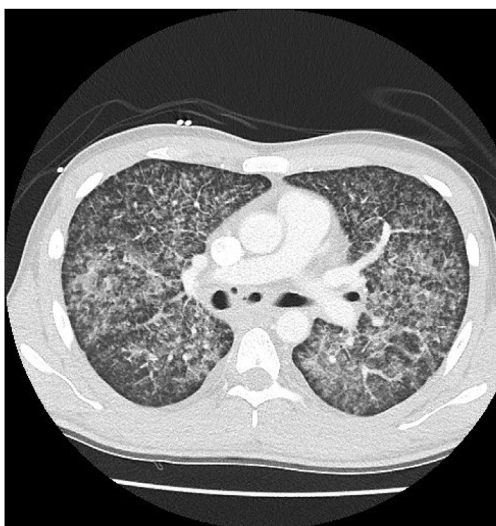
A CT scan the day after admission showing multiple nodular infiltrates. Mediastinal abscess not visible in this slide.
